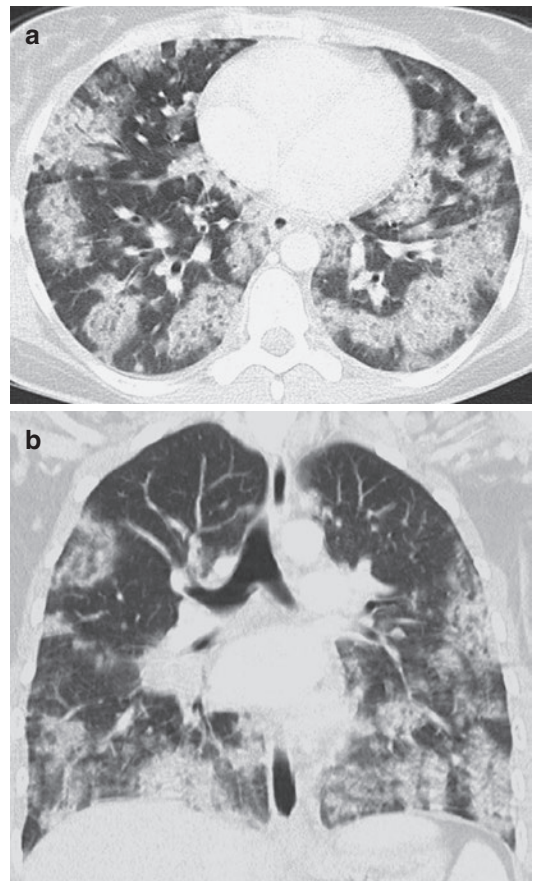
(a, b) Acute eosinophilic pneumonia in a 37-year-old female with BAL fluid eosinophilia. Axial CT image obtained 5 days after onset of dyspnea shows peripherally distributed patchy areas of consolidation and ground-glass opacities accompanied by interlobar septal thickening (a). Coronal CT image displays the lower lobe predominance of the infiltrates (b)
